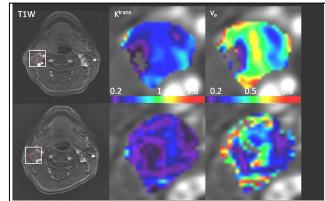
Pre- and intra- treatment DCE-MRI images of a patient with LF (male, 50y). The top row shows images of the pre-treatment study, and the bottom row shows images from the intra-treatment study.
